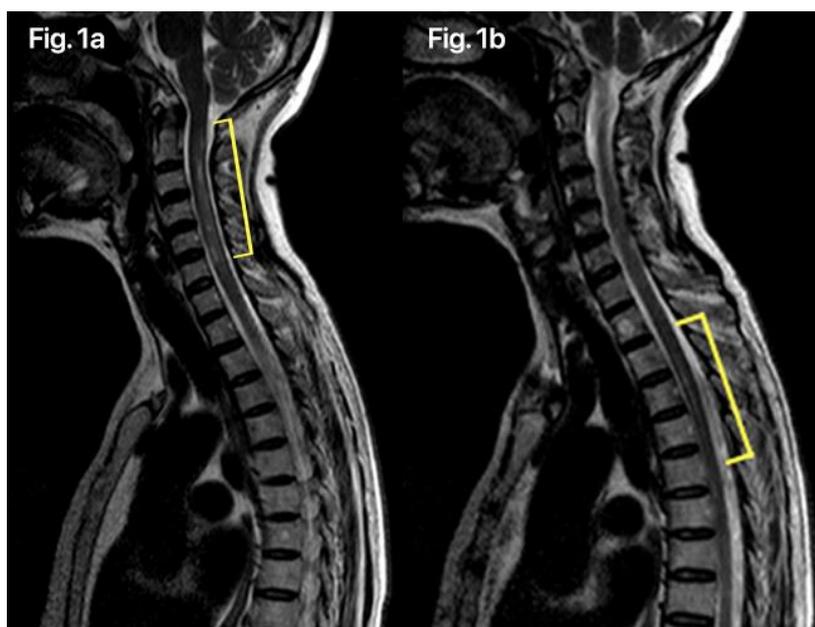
Spine sagittal view on non-contrast T2 weighted MRI. (a) Patchy hyperintensity on C2 – C6. (b) Hyperintensity on T2 – T5
